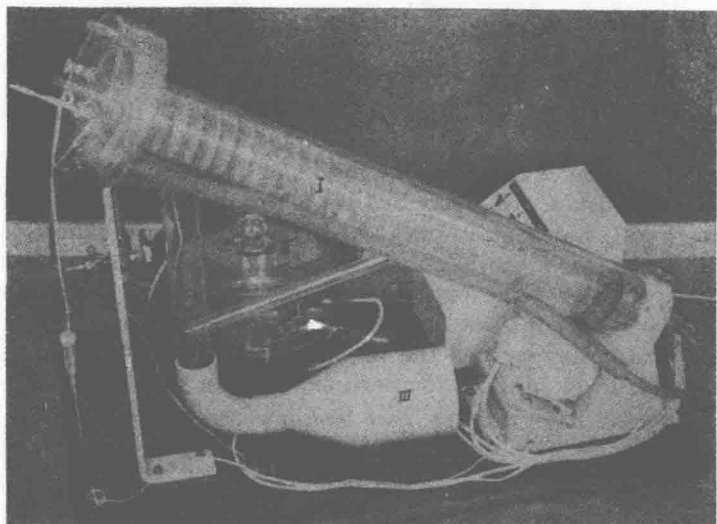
Perfusion apparatus. *I*, oxygenator; 1, spiral; 2, encasing cylinder; 3 and 4, inlets for artery catheters; 5, thermometer; 6, oxygen inflow; 7, oxygen flow meter. *II*, perfusion chamber; 8, inlets with rubber stoppers; 9, thermometer; 10, thermoregulated heating equipment; 11, perforated disk. *III*, thermocontrolled heating equipment for oxygenator. This apparatus is manufactured by KIFA AB of Stockholm and is distributed in the United States by Schick X-Ray Co., Inc., Chicago. (Courtesy of Westin, B., *et al.*: *Acta paediat.* 47:339-349, July, 1958.)
